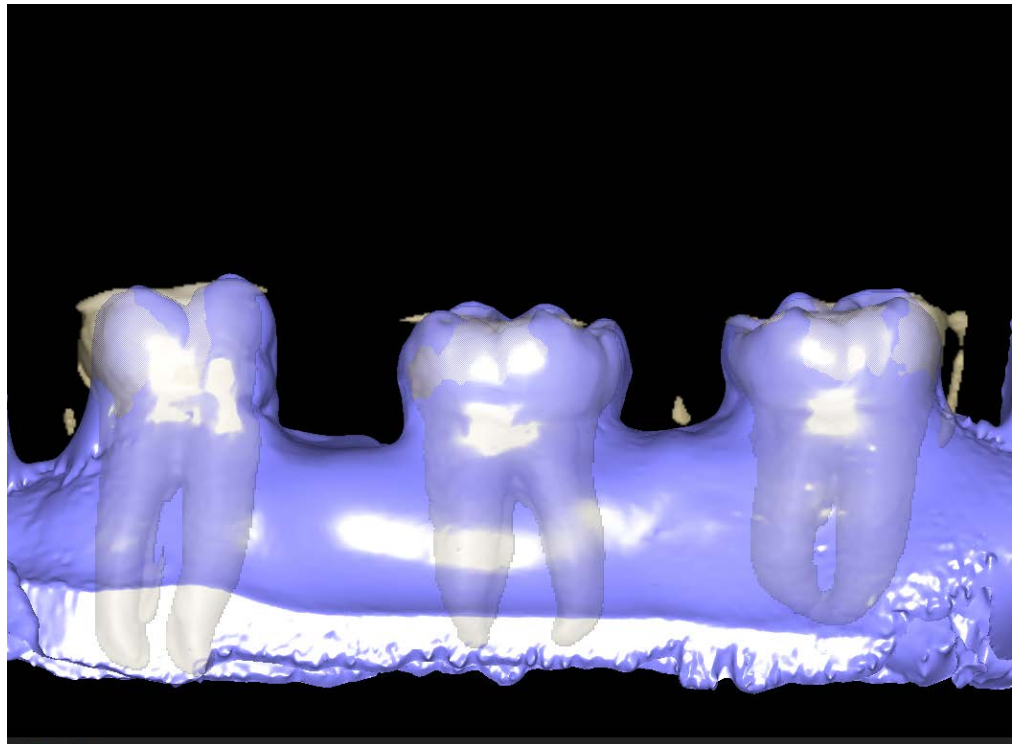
CBCT and intra-oral scans virtually merged.
